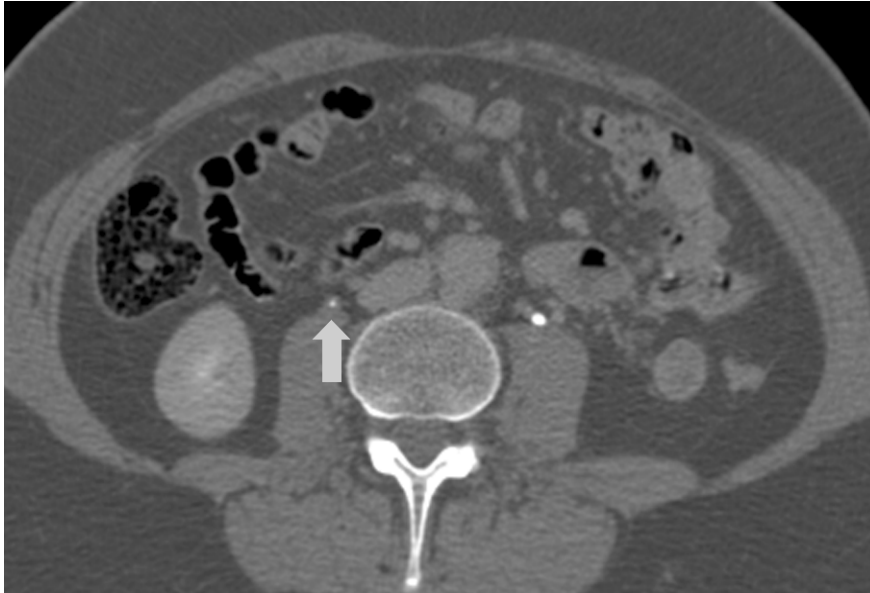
Axial excretory-phase CT urogram showing circumferential wall thickening of the right ureter caused by urothelial cancer.
